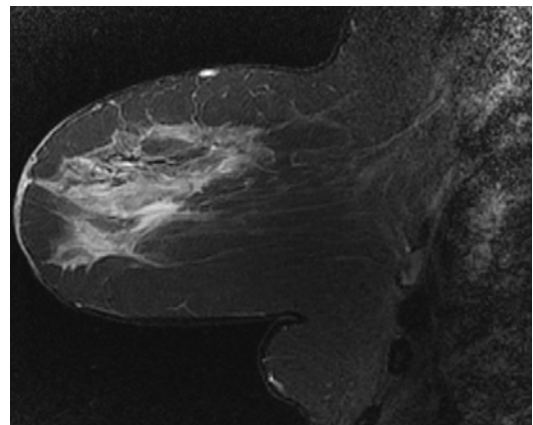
Abnormal MRI of the breast
